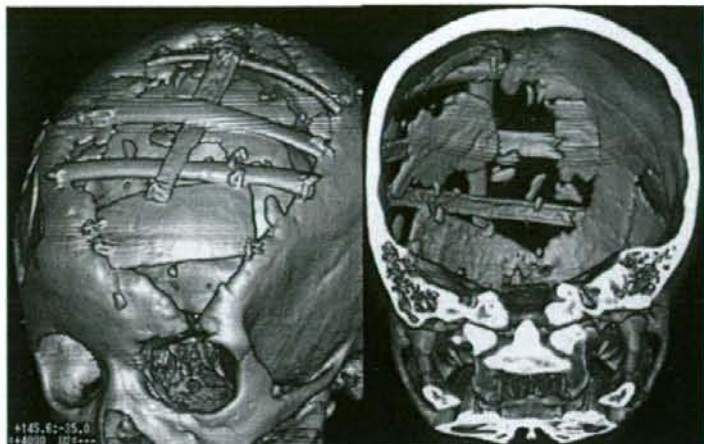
Patient 2—catcher's mask cranioplasty. A calvarial graft was placed to shape the forehead. The rib grafts were placed across each other. The 3-D CT scan was taken 6 days after the surgery. The islands of osteoanagenesis, observed at surgery, were used to shape the cranium
